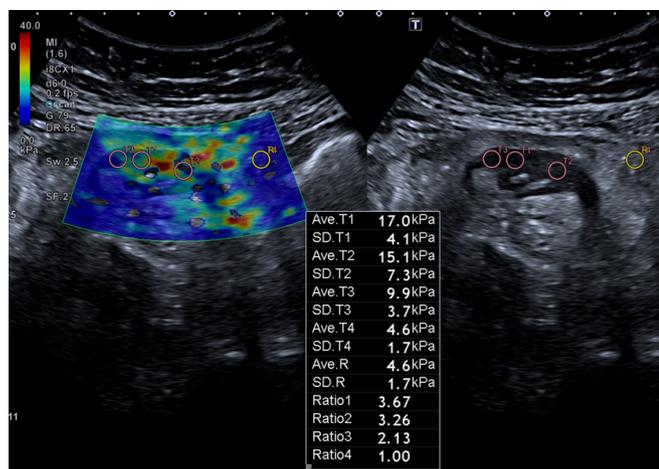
Real-time shear wave ultrasound image of stenotic bowel wall (left image) overlaying conventional ultrasound gray-scale images (right image) in a 38-year-old woman with CD. Multiple circular region of interest (ROI) are depicted over the bowel wall (T1–T3 and T4 [not seen on this image]) and in perienteric fat (R1). The quantitative data (average stiffness value in kPa and SD of each ROI, and ratio between bowel wall and fat) is automatically calculated. The color scale inside the box on the left image indicates the distribution of the measured elasticity within the area of interest. Ave, average.
